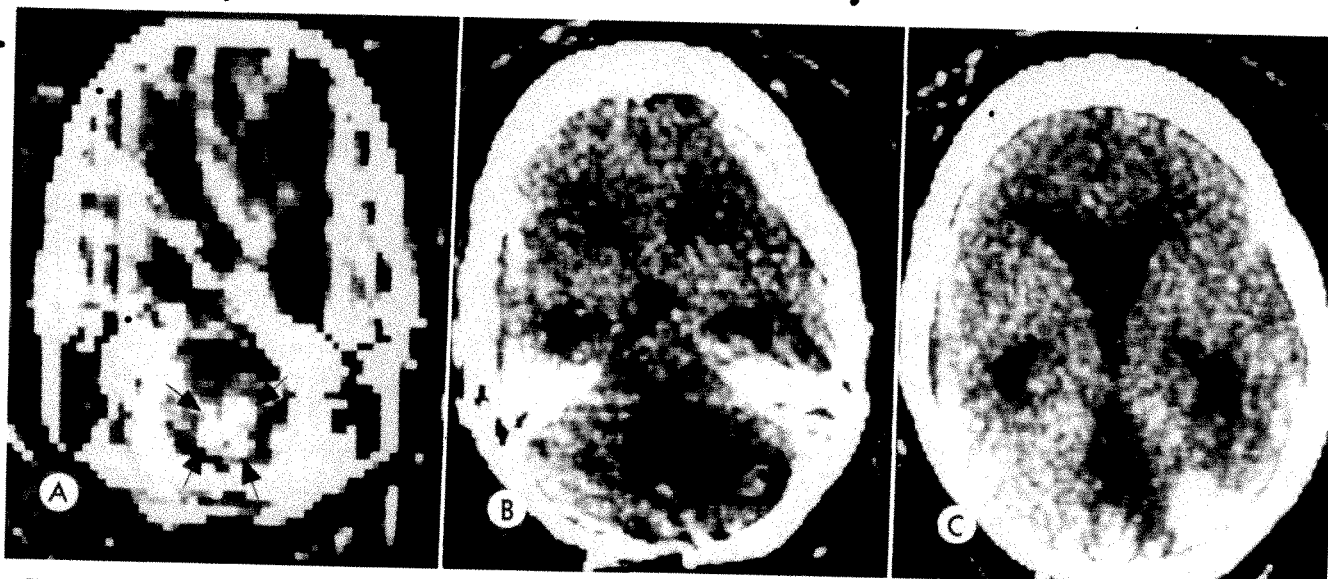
False positive cases. *A*, Suboptimal CT due to patient motion. Area of increased density in posterior fossa (arrows) thought to be tumor. Subsequent studies showed only aqueductal stenosis with normal fourth ventricle. *B* and *C*, Previous surgical removal of cystic astrocytoma. CT interpreted as recurrent tumor. At surgery no tumor present. There was an obstructed ventriculoperitoneal shunt with large fourth ventricle (area of decreased density on CT) and dural ossification (area of increased density) which was not visible on skull roentgenograms.
